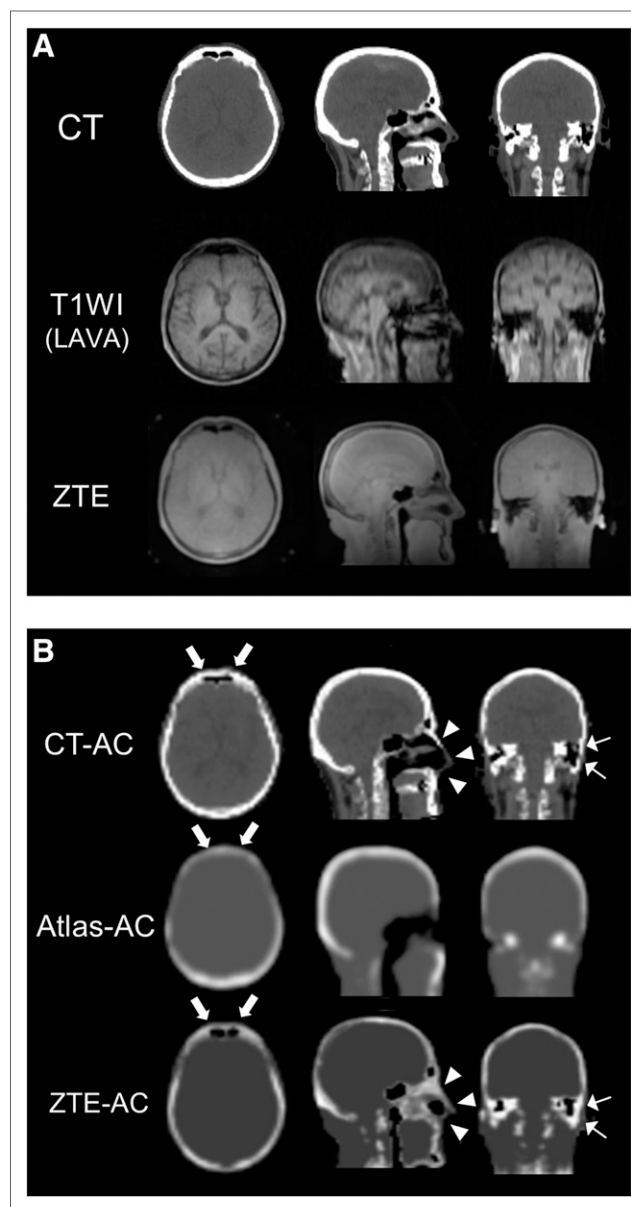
A representative case. (A) CT, T1w LAVA-Flex, and proton-density-weighted ZTE MR images are shown. (B) From each set of source images, 3 different attenuation maps were generated. Frontal sinus is not visible on atlas-AC (arrows, B). In nasal and mastoid areas, misclassification of bone is pronounced on ZTE-AC (arrowheads and thin arrows, B).
